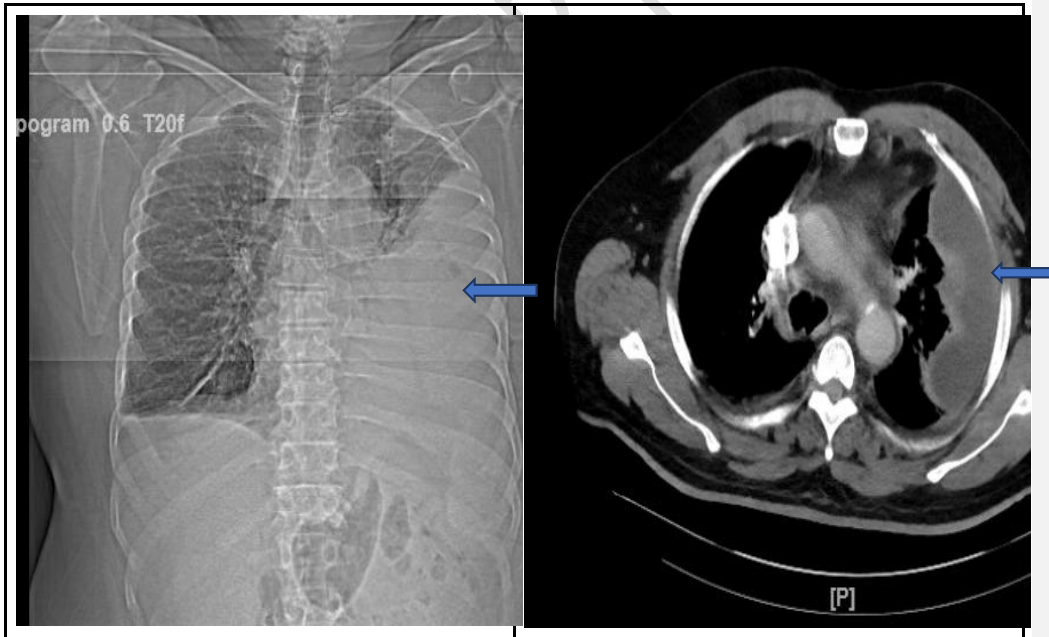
CT angiogram chest with contrast showing large loculated left pleural effusion (Blue Arrows)
